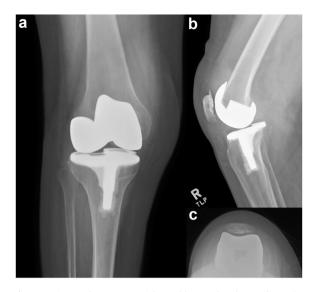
Six-month status post right total knee arthroplasty radiographs.
